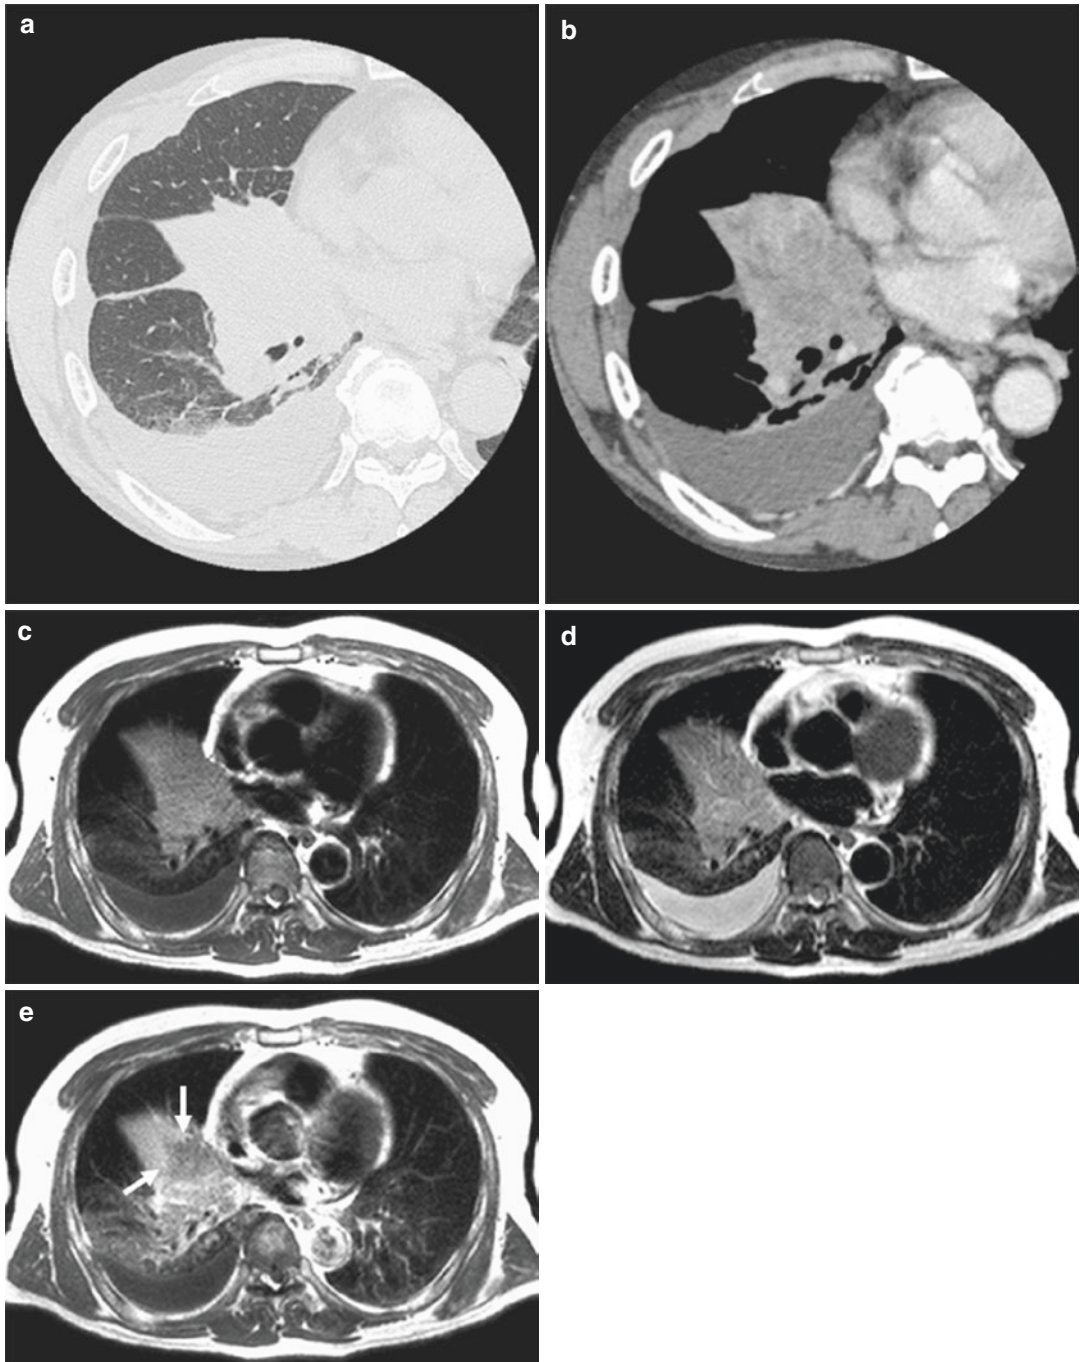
A 59-year-old male with adenocarcinoma. Thin-section CT (a) shows atelectasis in the right middle and lower lobe. Contrast-enhanced thin-section CT (b) shows homogeneously enhanced atelectasis and pleural effusion, but the extent of the tumor cannot be determined. Black-blood T1-weighted (c) and T2-weighted (d) images show
